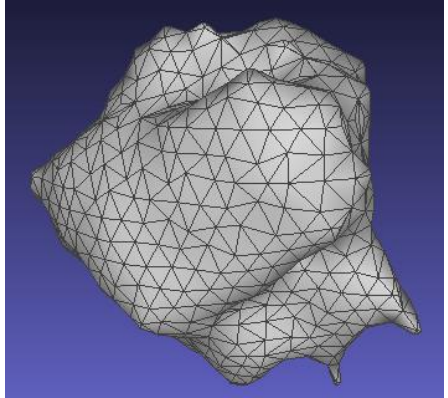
STL of the segmented tumor from MRI 05 using two smoothing steps in the Laplacian Smoothing tool in *Meshlab*.
